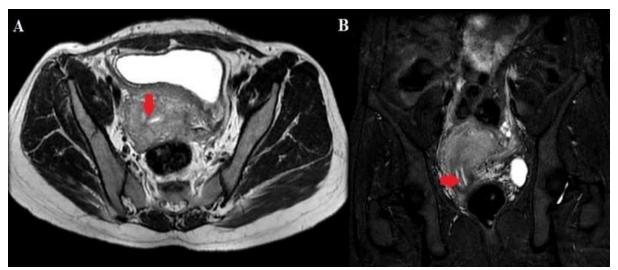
MRI images-T2W axial image shows two endometrial canals, completely separated by low signal intensity fibrous tissue (red arrow) with extension into endocervical canal (A); coronal STIR image shows two cervical canals, completely separated by low signal intensity fibrous tissue (red arrow) (B)
